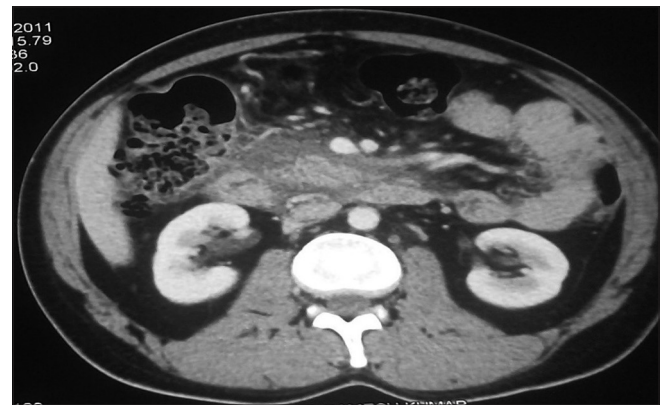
Axial section of contrast-enhanced computed tomogram of abdomen of the patient showing bulky head of pancreas with few small non-enhancing areas, peripancreatic fat stranding, minimal fluid collection and grossly atrophic body and tail suggestive of focal acute pancreatitis in the head region with chronic changes involving the pancreatic body and tail
